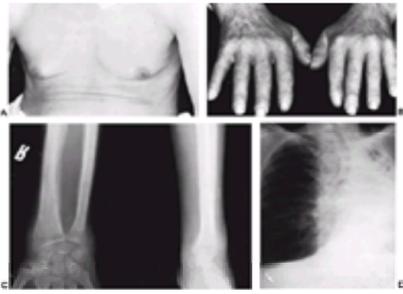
A 64-year-old man presented with dyspnea, (A) gynecomastia, (B) clubbing of the fingers, and tender wrists. (C) Roentgenogram of the forearm and wrist shows hypertrophic osteoarthropathy. Note the periosteal thickening of the long bones. (D) Chest roentgenogram shows complete atelectasis of the left lung. A scalene node biopsy was positive for anaplastic carcinoma.
